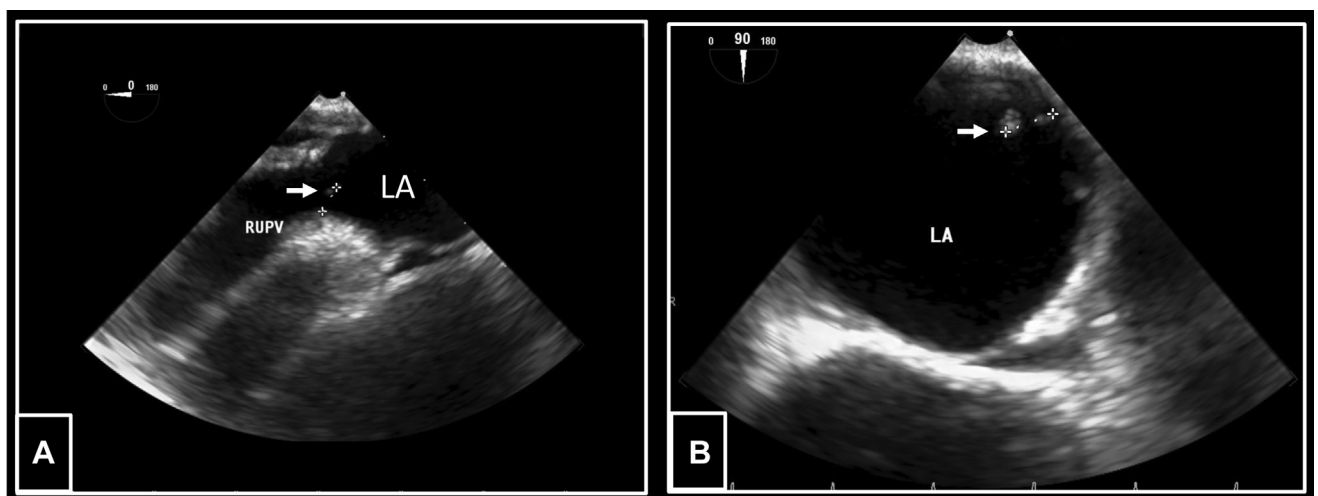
TEE-3. Transesophageal echocardiography after over a year of warfarin therapy with an elevated international normalized ratio goal of 2.5–3.5 demonstrating resistant thrombi. A: Image highlights a 0.47-cm thrombus adjacent to the right upper pulmonary vein (RUPV). B: Image displays a 0.56-cm thrombus at the roof of the left atrium (LA).
